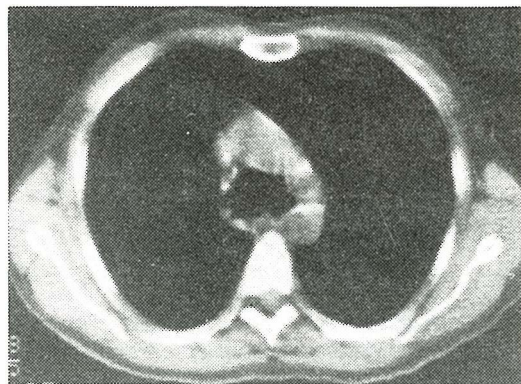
CT slice: marked dilatation of trachea and both main bronchi.
